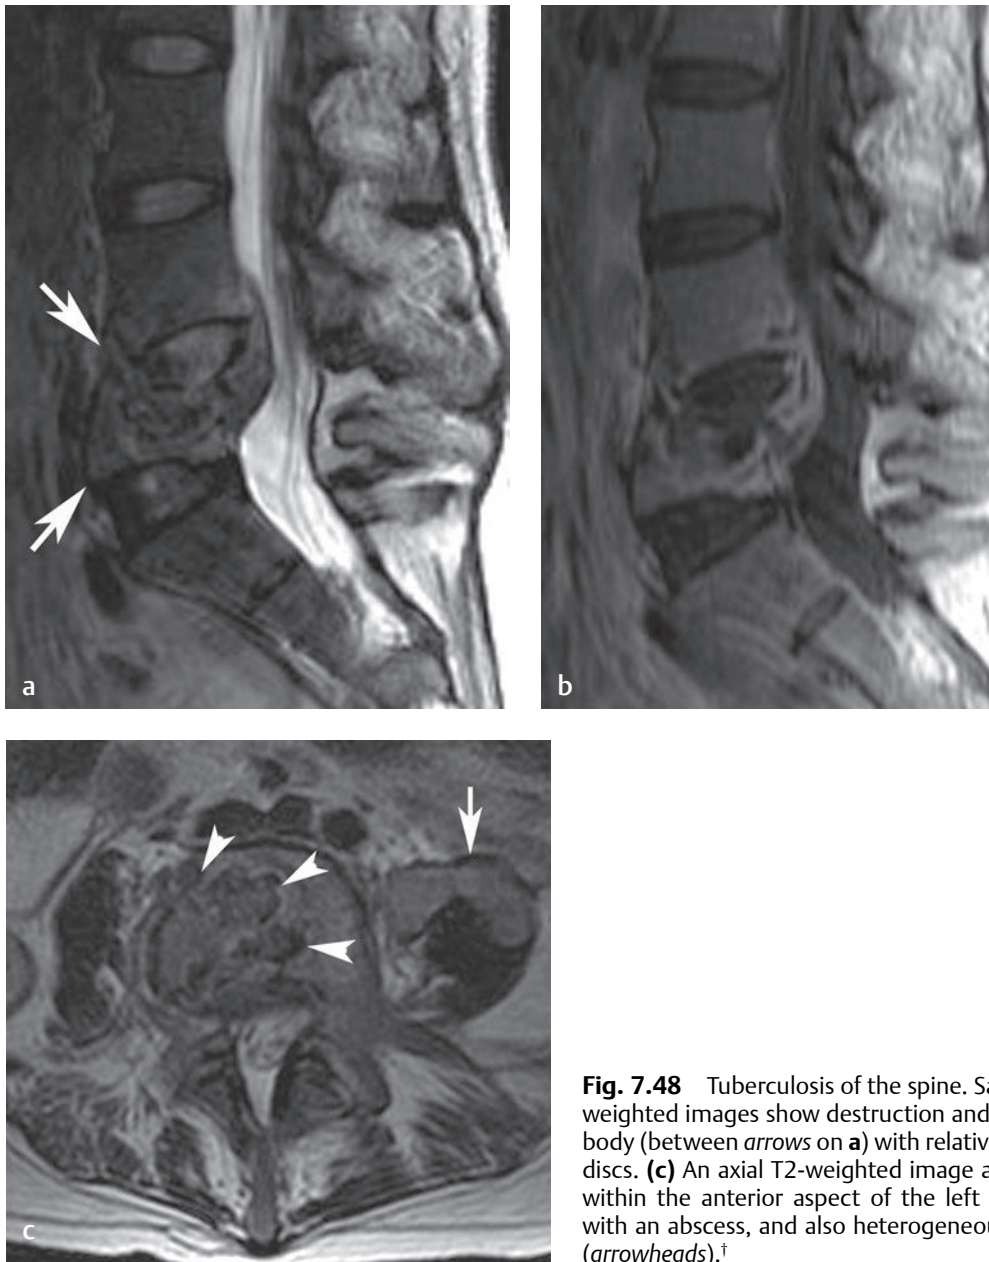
Tuberculosis of the spine. Sagittal (a) T2-weighted and (b) T1-weighted images show destruction and partial collapse of the L5 vertebral body (between arrows on a) with relative preservation of the intervertebral discs. (c) An axial T2-weighted image at the L5 level shows signal change within the anterior aspect of the left psoas muscle (arrow), compatible with an abscess, and also heterogeneous signal within the vertebral body (arrowheads).[†]
